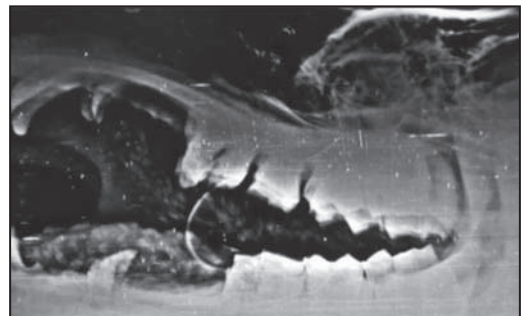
Radiographic evidence of interdental space (cheek teeth diastemata).
